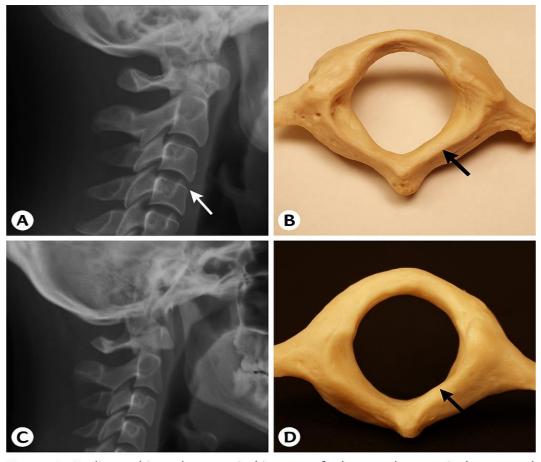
Radiographic and anatomical images of atlas vertebra ponticulus anomal
